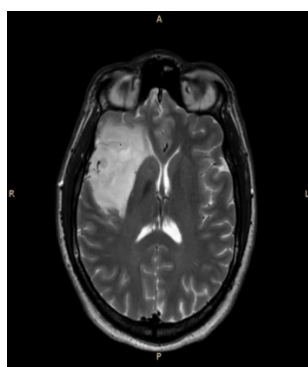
Brain CT scan of the fronto-occipital lesion.
